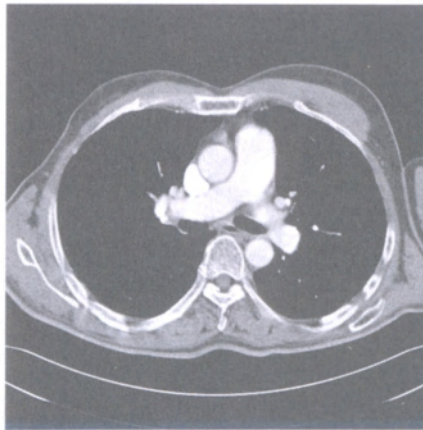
CT scan of the thorax
